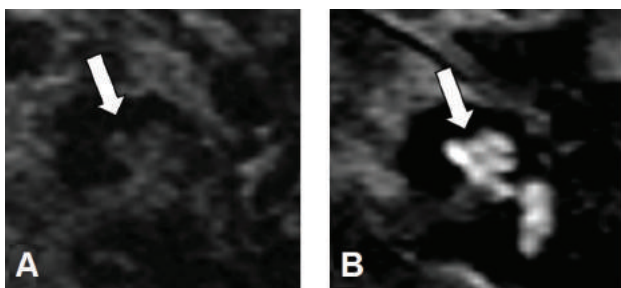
Axial gadolinium-enhanced T1-weighted MRI showing the normal situation without cochlear enhancement (A); severe cochlear enhancement caused by increased cochlear perfusion due to inflammation (B).
